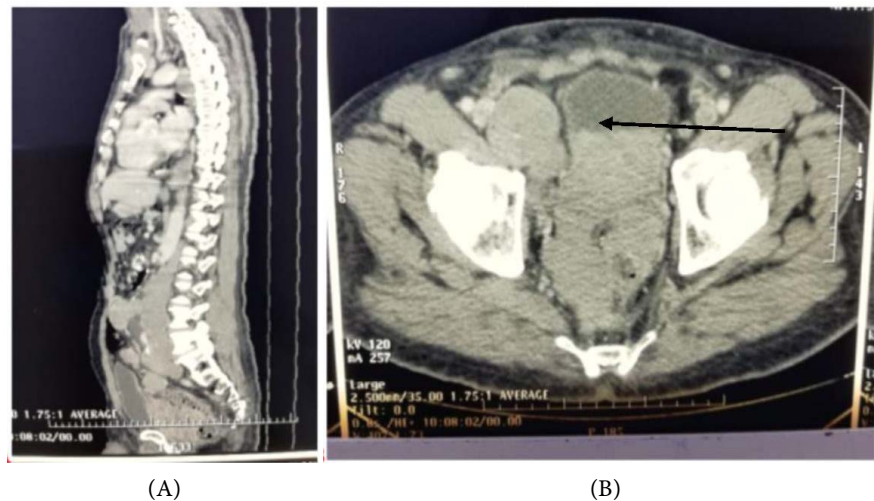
Sagittal (A) and axial slices (B) on pelvic CT scan showing heterogenous enlarged prostatic gland measuring 58 mm × 76 mm × 65 mm (149 cm³ in volume).
